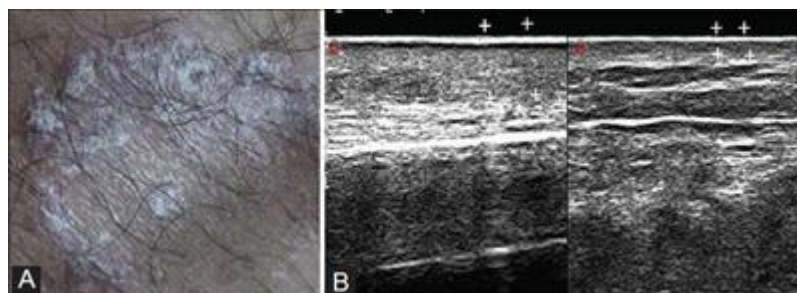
Ultrasonography examination of psoriatic plaque showing thickened hyperechoic epidermis and dermis compared to contralateral skin, as the superficial scales produce a hyper-reflective epidermal band [50]
